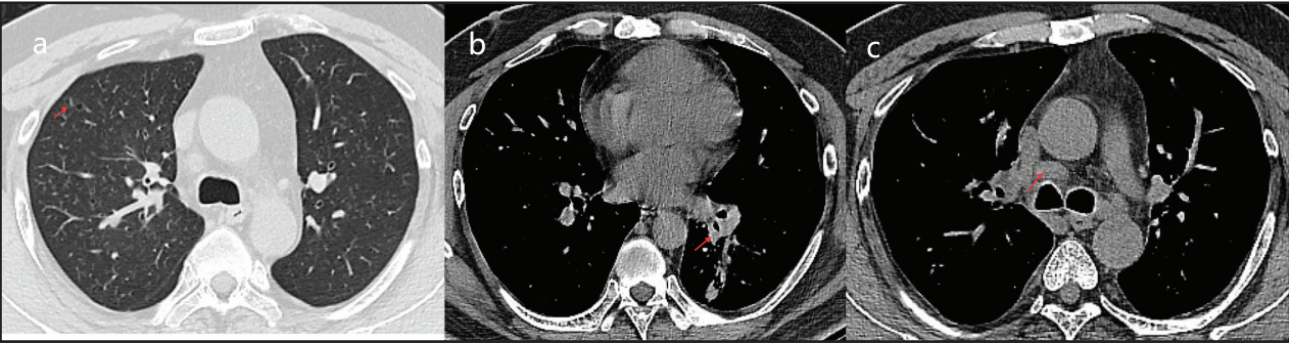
Chest CT (January 16, 2026). (a) Lung window showing partial reduction or disappearance of the bilateral multiple small cystic lesions. (b and c) Mediastinal window showing reduction of the left lower lobe mass and of the mediastinal lymphadenopathy compared with baseline.
